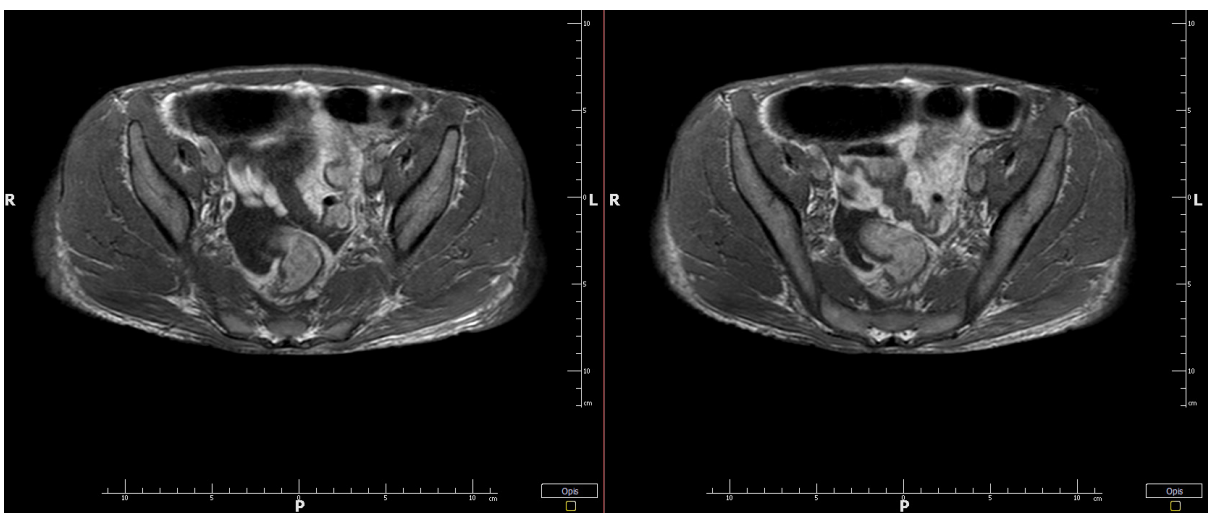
An MRI Image of the abdomen and pelvis revealed the thickening of the walls of the cecum and the ascending colon and the ileocecal valve area with a slight fluid reaction in the environment - inflammatory lesions and the perianal fistula canal.
